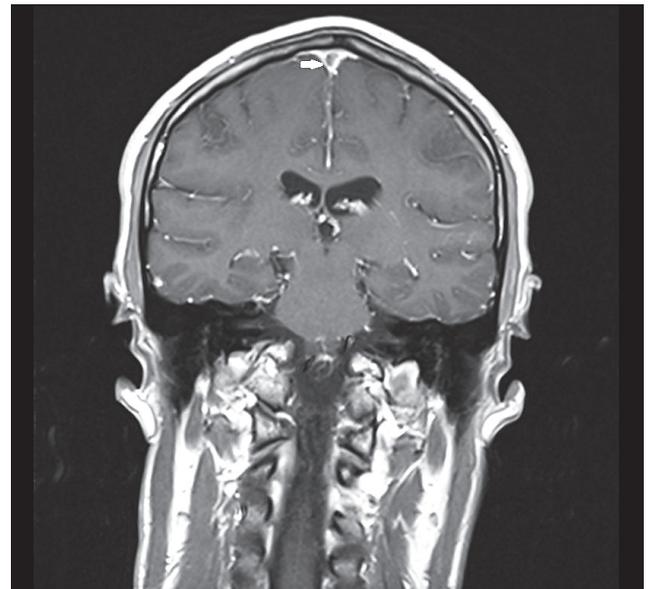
T1-weighted image + CM, coronal plane. ‘Empty delta sign’
